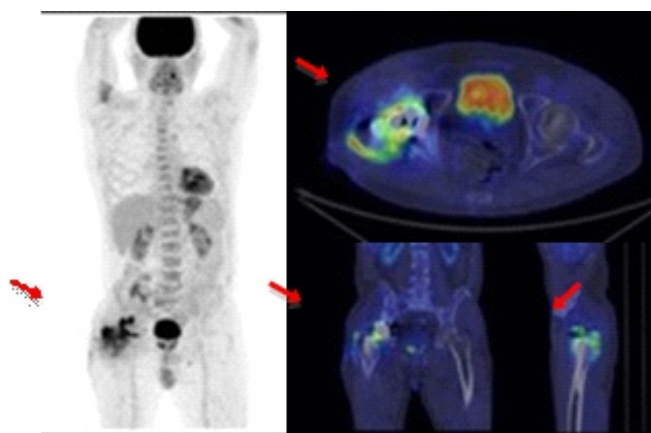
Previous implant of right hip prosthesis. Recent appearance of fistula on intervention's site. Fluorine-18-FDG PET/CT: typical pathological uptake in the periprosthetic soft tissues of the right hip.
